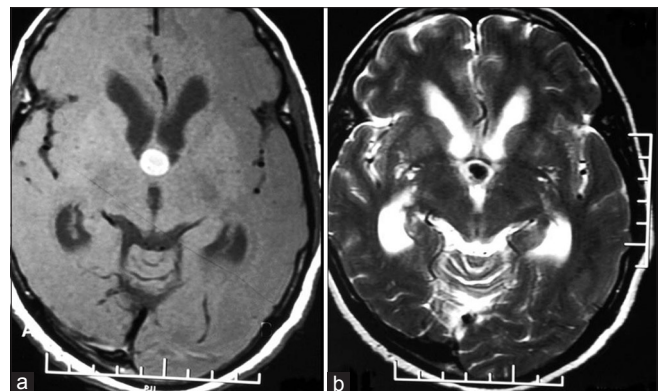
Axial CT (a) and T2-weighted MRI; (b) Large colloid cyst in a young patient with features of obstructive hydrocephalus. Though this tumor was seen at the foramen of Munro, a suprachoroidal approach was required to completely excise the tumor
